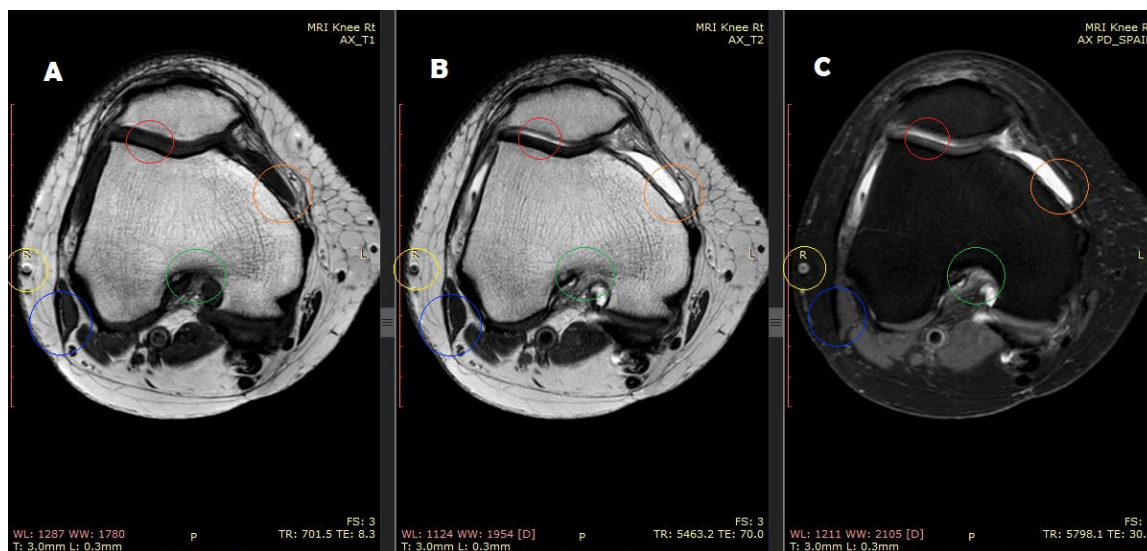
Axial MRI images of the knee in different image Weights: A - T1 Weighted; B – T2 weighted; C – PD Weighted with fat saturation. Different images’ Weights allow the observer to characterize different tissue and structured by: first by matching the observed signal intensity of the structure/tissue, on the identified Weight of the image, against the expected signal intensity of the same structure/tissue in the observer’s mental visualization/construct of the ideal image’s Weight; and second by comparing the signal intensity of the structure/tissue against its signal intensity on other available image’s Weight. The green circle demonstrates how the boundaries between different tissues can either be easily seen (C) or not seen at all (B) depending on the observed image’s Weight. The Yellow circle demonstrates how Chemical Shift artefact is present in T1 (A) & T2 (B), but gets corrected in images with fat saturation (C). The Red circle demonstrates how T1 Weight (A) is unable to differentiate properly between cartilage and water compared to B & C. In addition it also shows that cartilage has much higher signal intensity in PD (C) Weight than T2 (B). The Fat saturation component of image C just further enhances the contrast between cartilage and other tissues. This is why PD_FS (C) is a very important image Weight for joint assessment. The Blue circle demonstrated how fat saturation can also be detrimental by reducing the contrast between fat tissue and other tissues that have low signal intensity (e.g. Ligaments) (C), compared to non-fat saturated images (A & B). Lastly the Orange circle demonstrates how image’s Weight with high contrast can sometimes lead to a loss of image detail (A &C) in areas of very small/narrow structures, making Weights with softer/lower contrast (T2) better to assessment these areas.
